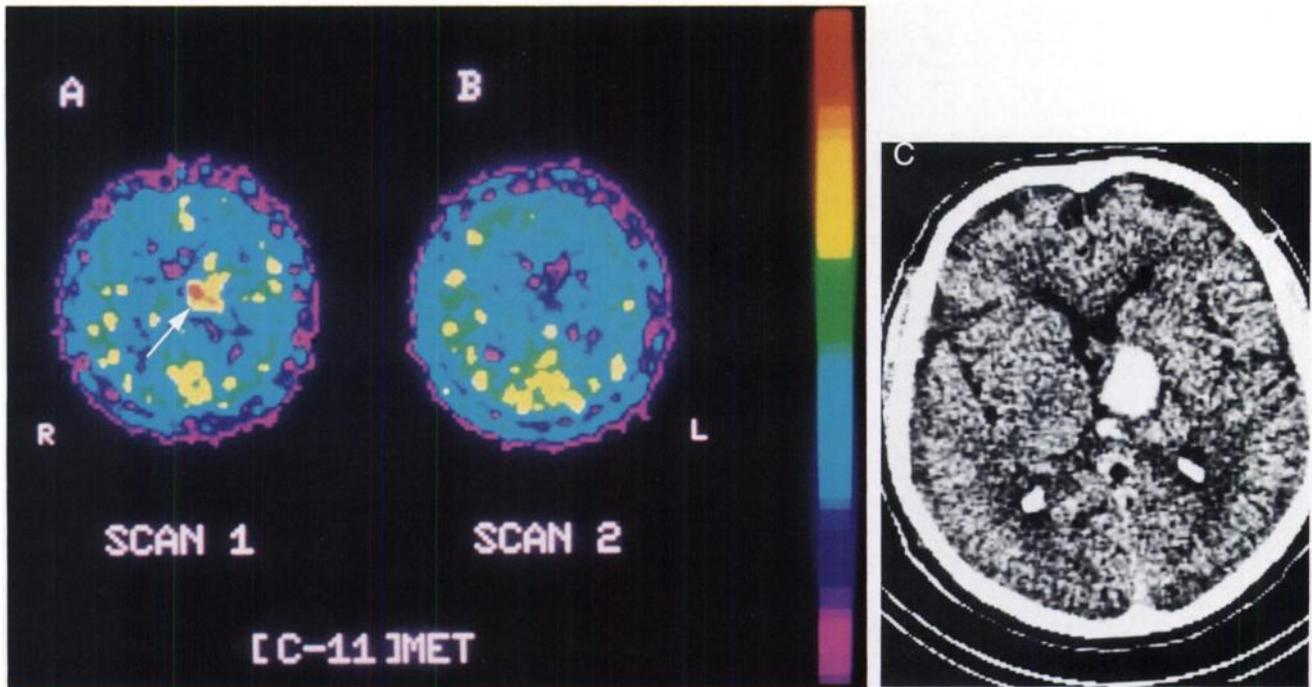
Patient 3. (A) Carbon-11-methionine PET image obtained 21 days after the hemorrhage shows high uptake of the tracer in the area of the left thalamic hematoma (right part of the image, arrow). (B) Carbon-11-methionine PET image obtained 76 days after the hemorrhage shows disappearance of increased uptake in the area of the hematoma (right part of the image). (C) CT at a level similar to the PET image shows a spontaneously hyperdense lesion in the left thalamus.
